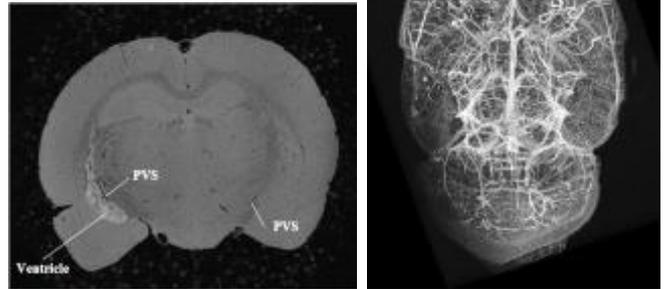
(Left) 2D MR image showing gadolinium-labeled albumin tracer in the ventricle and PVS. (Right) 3D reconstruction of the vasculature. Vessels were then segmented and reconstructed in 3D using maximum intensity projection.
